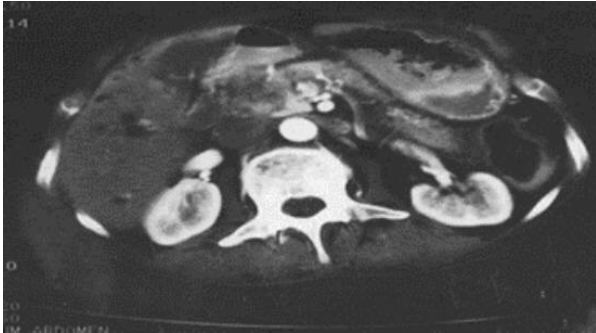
Pre radiofrequency ablation contrast enhanced computed tomography demonstrating large pancreatic head malignancy.
